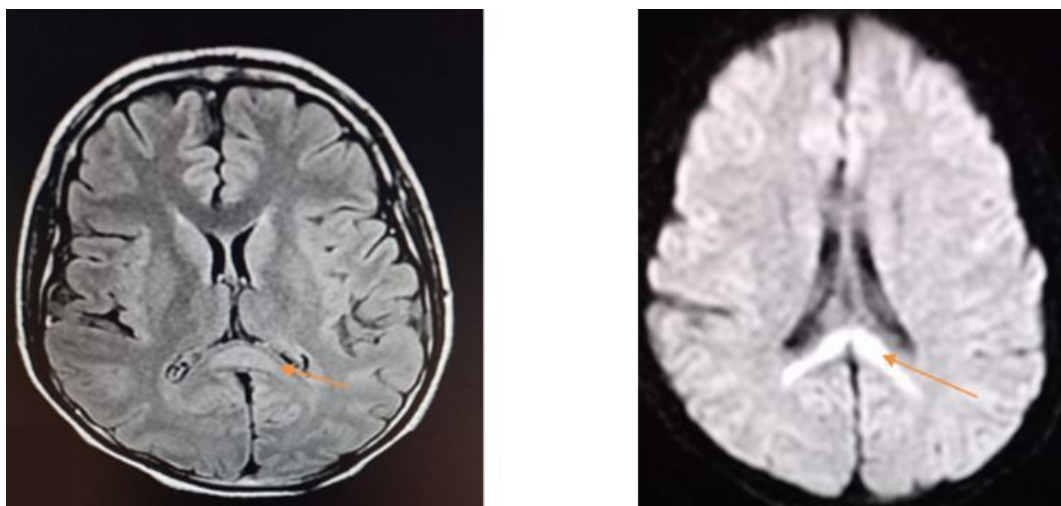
MRI brain (plain+contrast) showed cytotoxic lesions of corpus callosum
